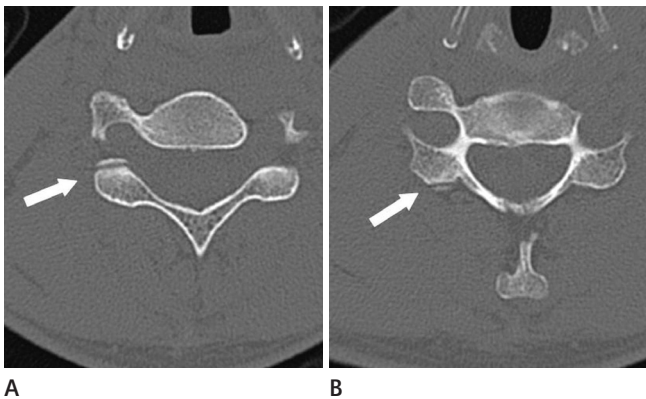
CT scan of the cervical spine. The bony projections arose from the anterior tubercles of the right transverse processes (arrows). There is no evidence of bone fracture.
